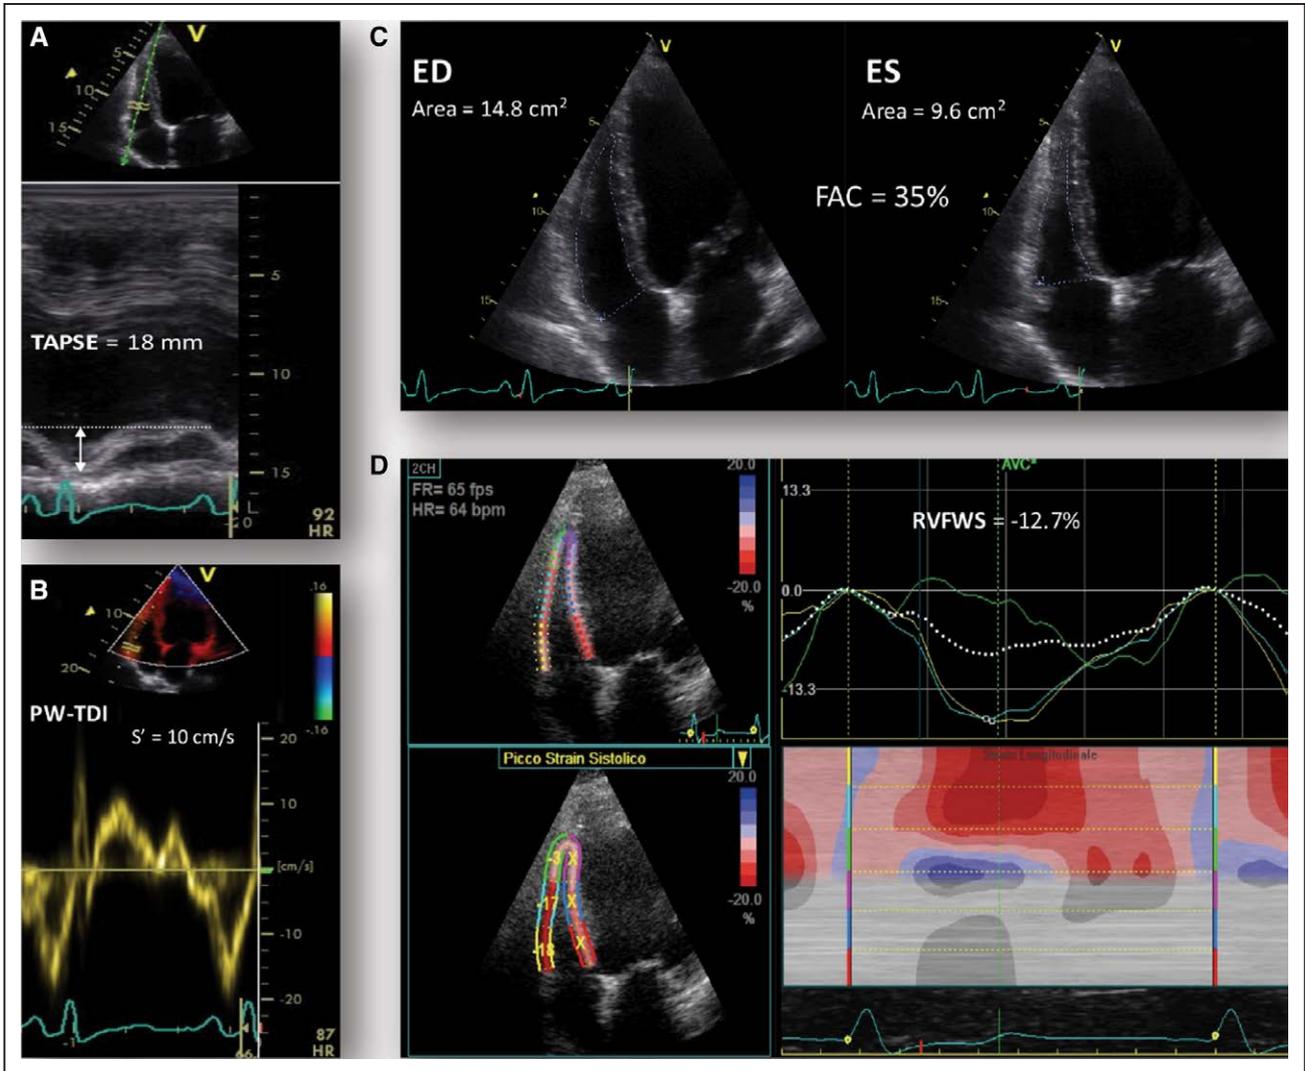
Determination of right ventricular (RV) systolic function in a typical patient. RV function was normal by (A) tricuspid annular plane systolic excursion (TAPSE) and (B) S' by Pulsed-wave Tissue Doppler Imaging, slightly reduced by (C) RV fractional area change (FAC=35%) and clearly reduced by (D) longitudinal RV strain (RVFWS, -12.7%). ED indicates end-diastolic; ES, end-systolic; FR, frame rate; and HR, hazard ratio.
